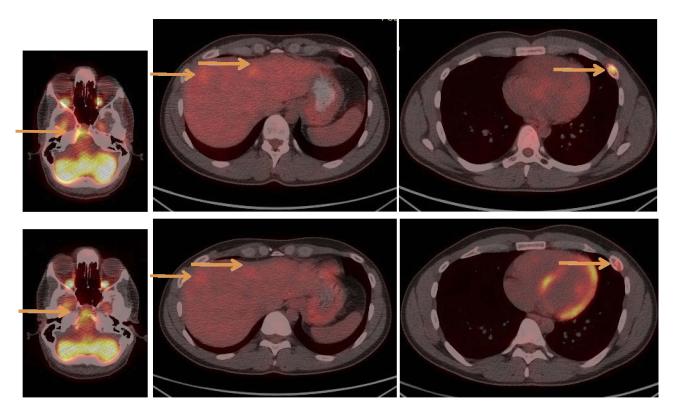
Figure I FDG PET/CT of patient I. Upper line showing clivus, liver and rib lesions before therapy and lower line showing the same lesions after the administration of 6 cycles of Doxorubicin plus Olaratumab. Arrows highlight the lesions.
